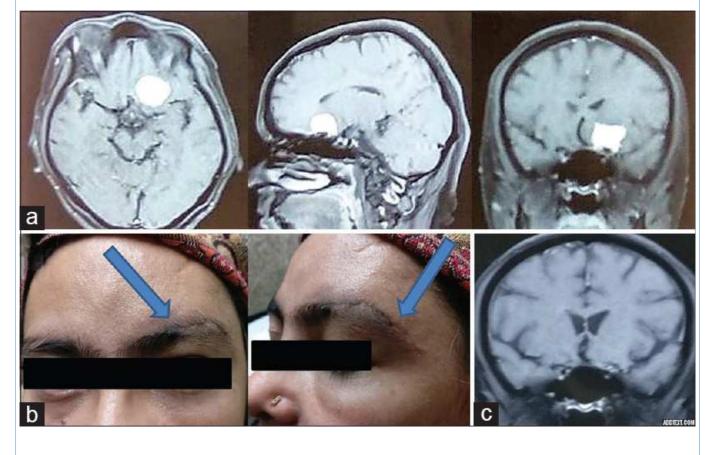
(a) MRI brain postcontrast images of a 40-year-old female with a suprasellar meningioma, which was off the midline. It was excised via the supraorbital approach. (b) Clinical picture postoperatively showing the suparaorbital scar (Blue arrow). (c) Postoperative MRI showing complete excision
